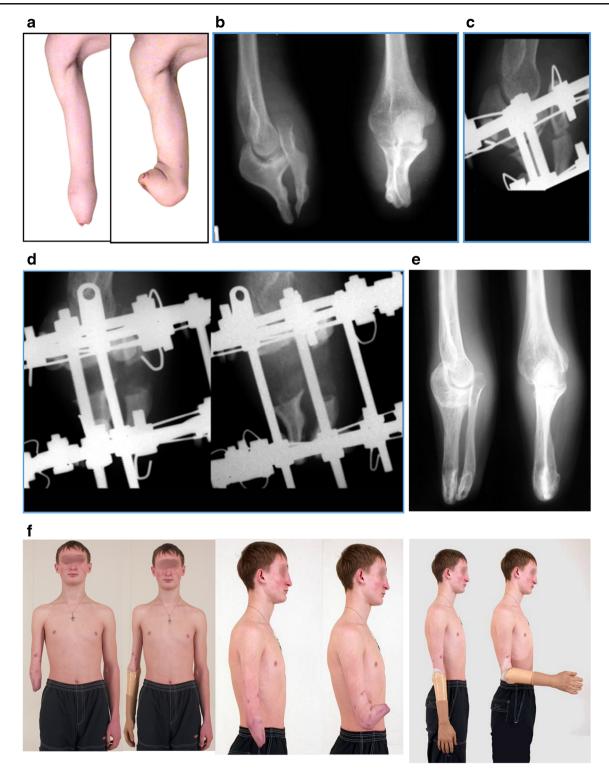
Boy of 15 years with congenital forearm amputation: \mathbf{a} upper limb before treatment; \mathbf{b} radiographs of forearm stump before lengthening; \mathbf{c} in the beginning of distraction period; \mathbf{d} progressive lengthening of both
